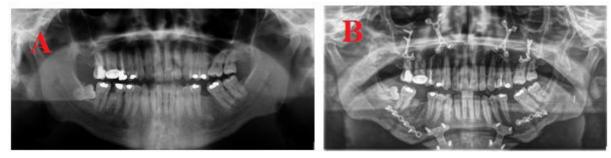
Panoramic X-ray (A) Pre- and (B) Post-operative following MMA.
